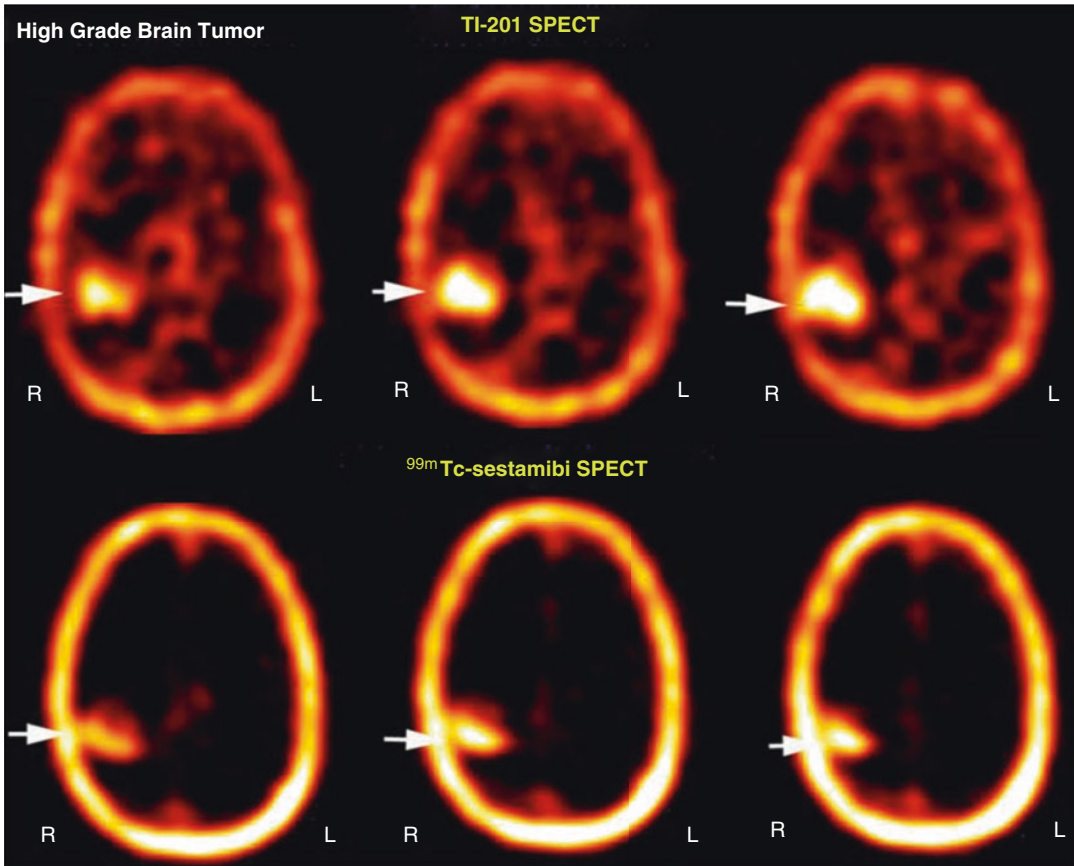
^{201}Tl and $^{99\text{m}}\text{Tc}$ -MIBI SPECT scans of a 45-year-old female with high-grade brain tumor in the right temporal lobe who had recent chemotherapy and who had low $^{99\text{m}}\text{Tc}$ -MIBI uptake in the tumor, compared with ^{201}Tl . This case compares the diagnostic capability of ^{201}Tl SPECT (*top row*) as compared with $^{99\text{m}}\text{Tc}$ -HMPAO
